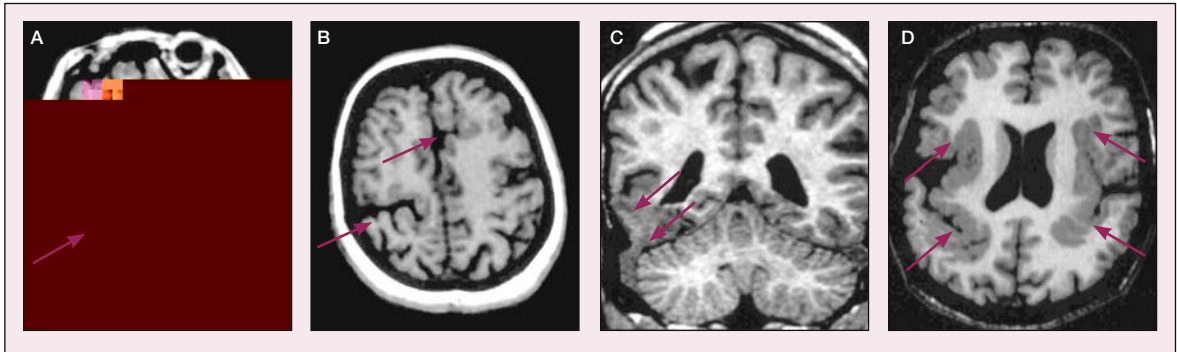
(A,B) Axial T1-weighted MRI scan showing bilateral schizencephaly (arrows). (C) Coronal T1-weighted MRI scan showing right focal cortical dysplasia (arrows). (D) Axial T1-weighted MRI scan showing bilateral perisylvian polymicrogyria (arrows). Courtesy of Professor John S. Duncan and the National Society for Epilepsy MRI Unit, UK.
